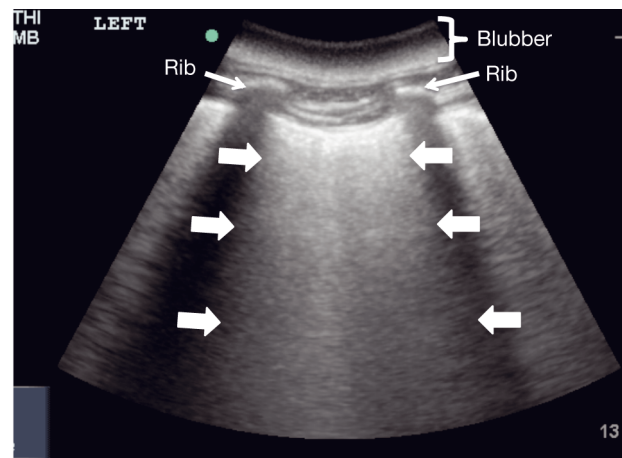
Representative dorsal plane ultrasound image of an area of dolphin (*Tursiops truncatus*) lung affected with severe alveolar-interstitial syndrome (AIS). Contiguous ring-down artifacts create a 'white-out' appearance (white block arrows). Green dot designates that cranial is to the left and caudal is the right
